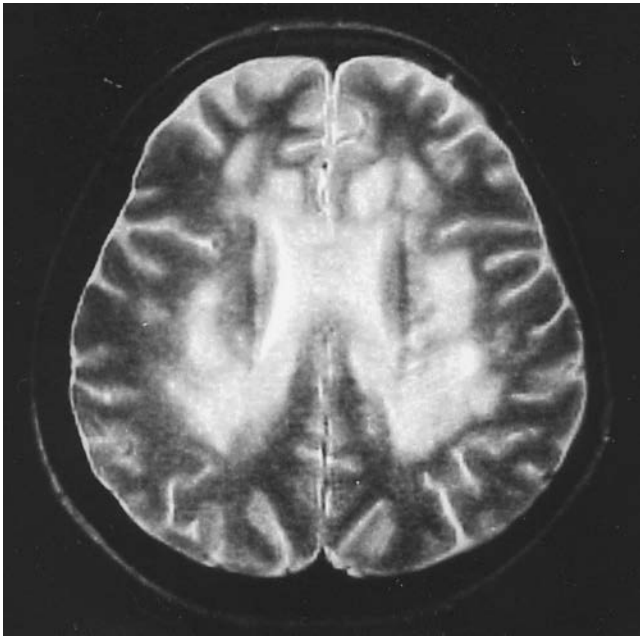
Magnetic resonance imaging (T2 weighted) of the brain in a woman with pernicious anemia and cognitive dysfunction. Large confluent and focal areas of increased signal intensities are seen, predominating around the ventricles. The changes improved after therapy. (From Stojsavljevic N, Levic Z, Drulovic J, et al. A 44-month clinical-brain MRI follow-up in a patient with B₁₂ deficiency. *Neurology* 1997;49:878–881, with permission.)
